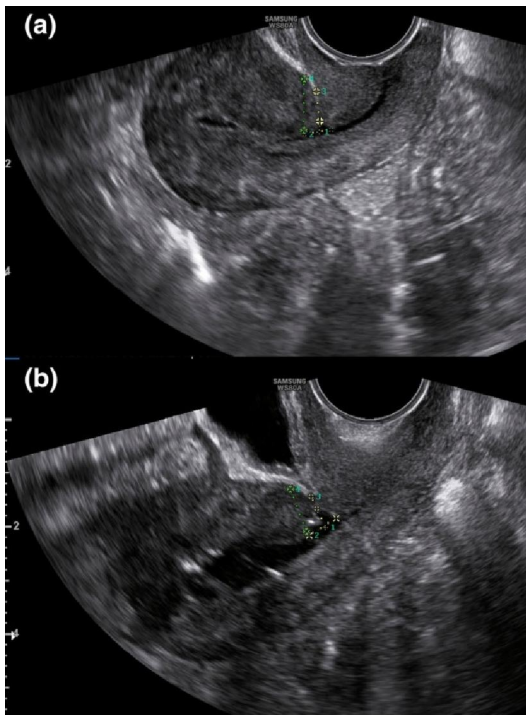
An isthmocele which seems to be unimportant with transvaginal ultrasonography (a) but which reveals a more obvious defect with sonohysterography (b).
